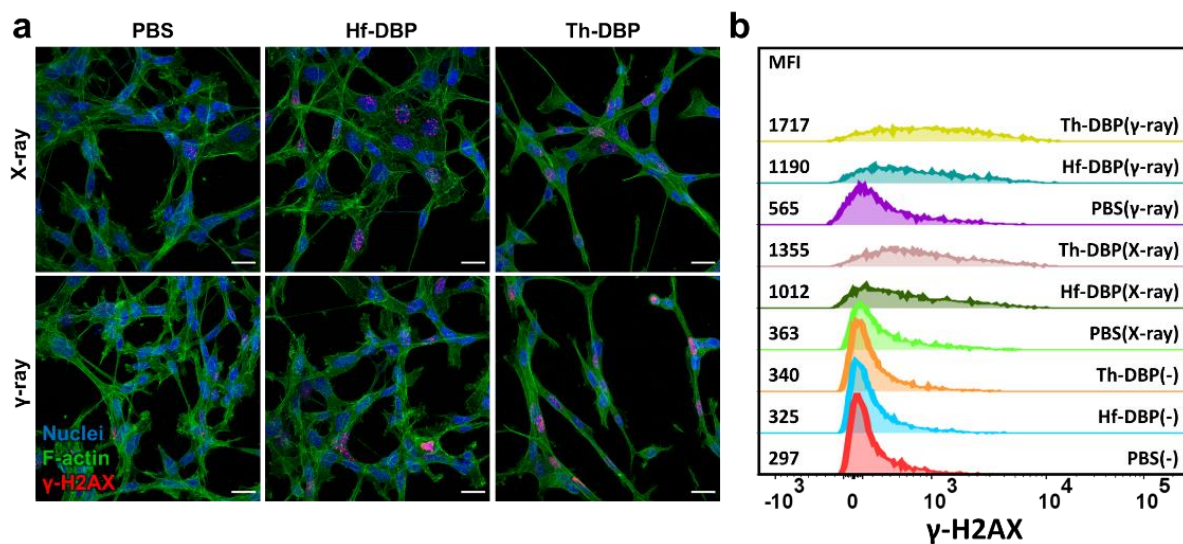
DNA DSBs in cells. (a) CLSM images and (b) flow cytometric histograms of CT26 cells showing DNA double stranded breaks (DSB) labeled by γ -H2AX 24 hours after 2 Gy X-ray or 4 Gy γ -ray irradiation, respectively (scale bar = 20 μ m).
